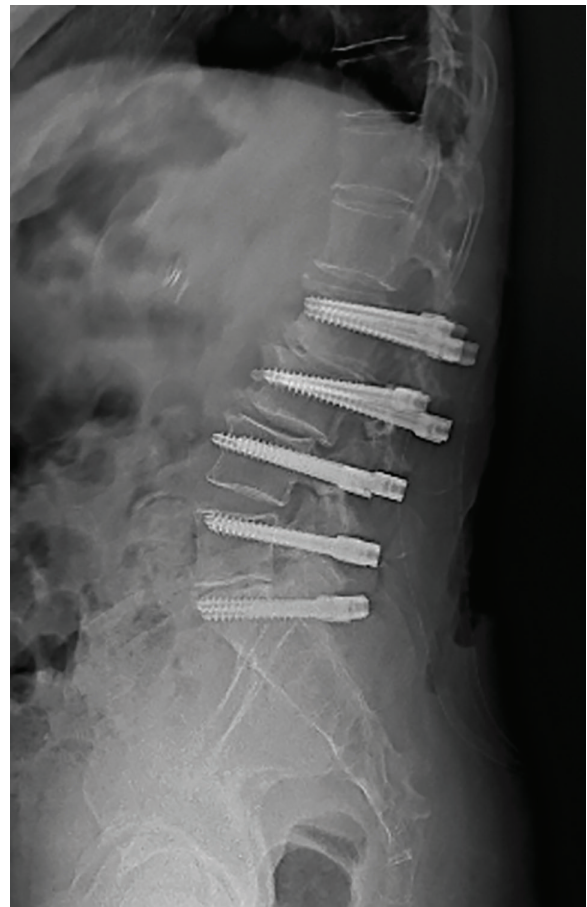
Lateral x-ray image after surgery shows the connection of the Dynesys system after osteointegration.
